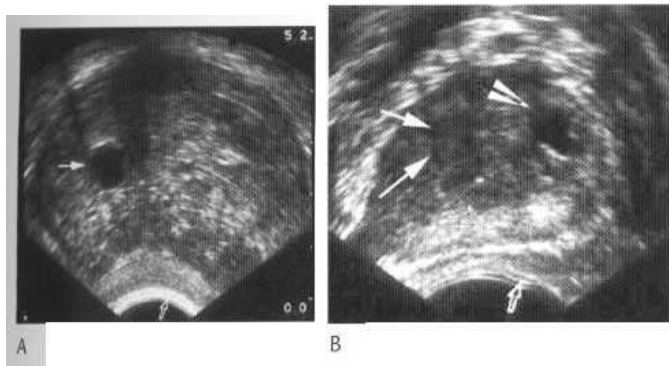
Transrectal ultrasound (transverse images) on patients with benign prostatic hyperplasia. (A) shows marked prostatic enlargement. The central gland shows a multinodular appearance with a benign cyst (arrow) and gross enlargement. This has displaced and compressed the more echogenic peripheral zone. (B) shows more modest disease with less central gland enlargement. A benign cyst (arrowhead) and an adenomatous nodule (arrows) can be identified.
